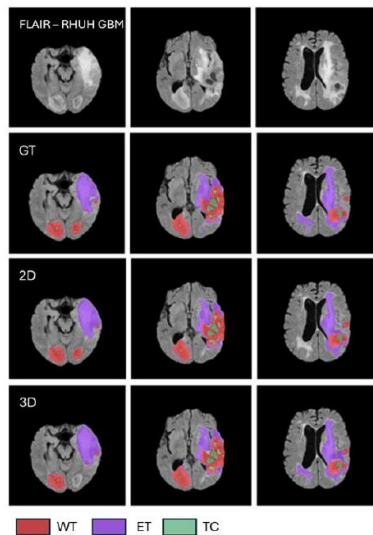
Post-MBL2D(RH) and Post-MBL3D(RH) performance in recurrence cases. Top row: RHUH post-operative FLAIR scan showing signal change due to a high-grade glioma. Second rows: GT segmentations across glioma subregions: WT, ET, and TC (colour-coded). Third and bottom rows: 2D and 3D predictions, respectively, after fine-tuning. (n=8)
